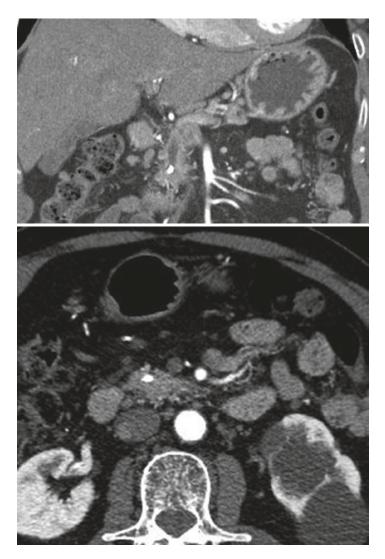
CT of the pancreas notes a pancreatic ductal head stone with proximal pancreatic duct dilation
